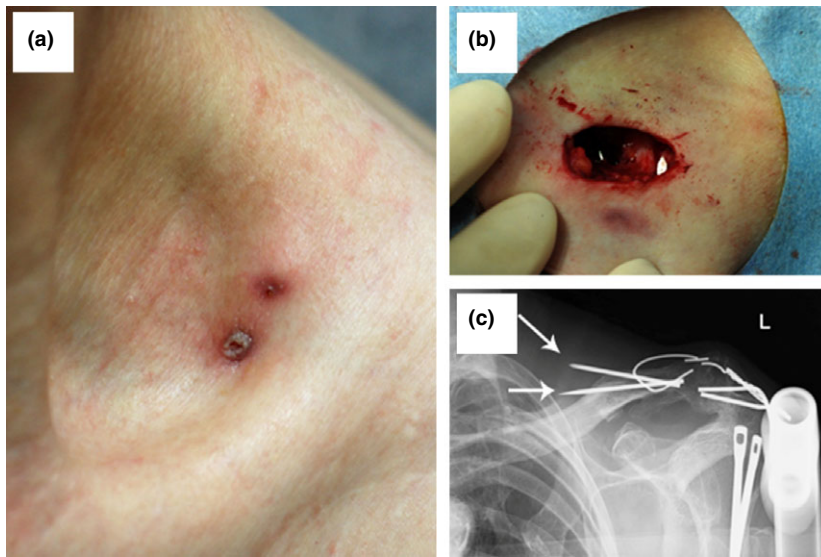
(a) Two ulcers, 5 mm and 2 mm in diameter, are observed on the patient's left supraclavicular fossa. (b) The tips of metal implants were found during the procedure of excisional biopsy of the ulcers. (c) A plain X-ray image revealed broken metal implants in the left clavicle. The tips of the implants were close to the skin surface (arrows).
